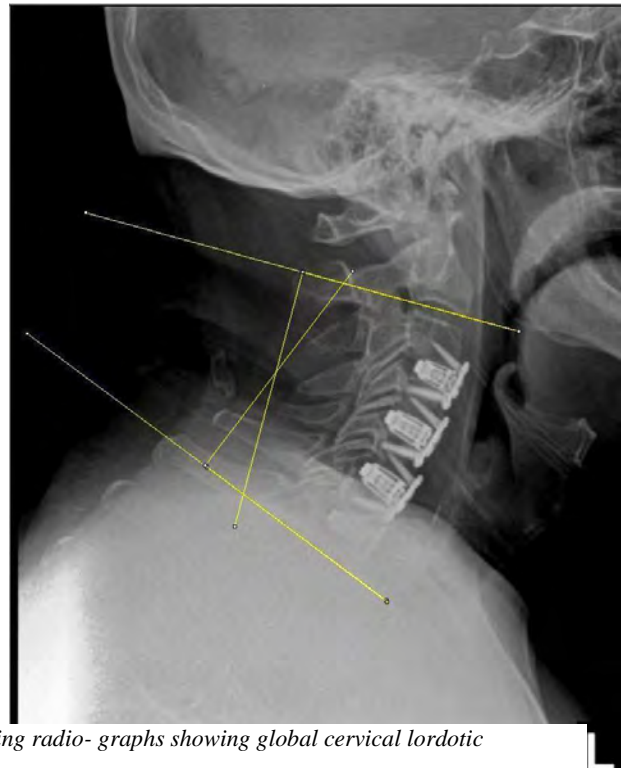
and 4 b: Pre- and post-operative standing radiographs showing global cervical lordotic improvement
